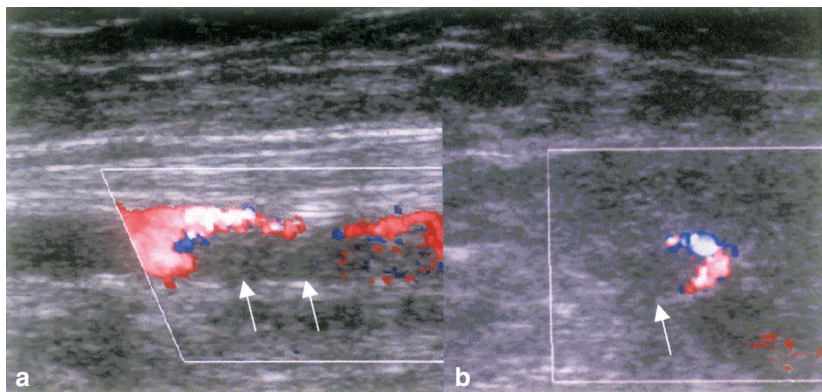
Embolus in color Doppler US: flow void (arrows) with a rounded shape in the longitudinal (a) and in transversal (b) planes. Typical location of an embolus is usually above a bifurcation.
